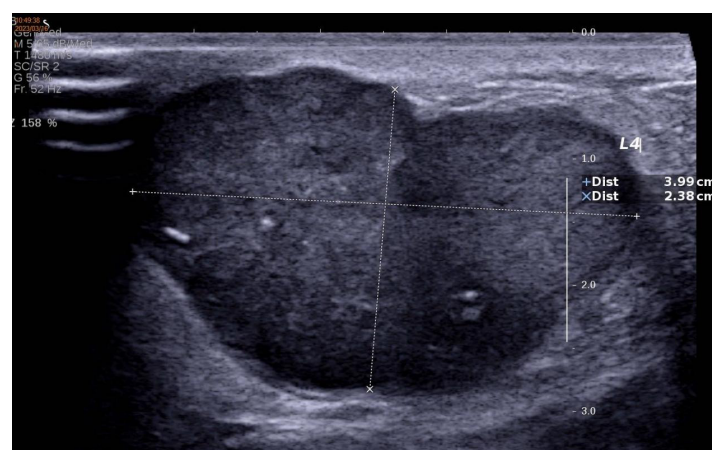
Automatic full-volume breast ultrasound scan of superficial small organs
